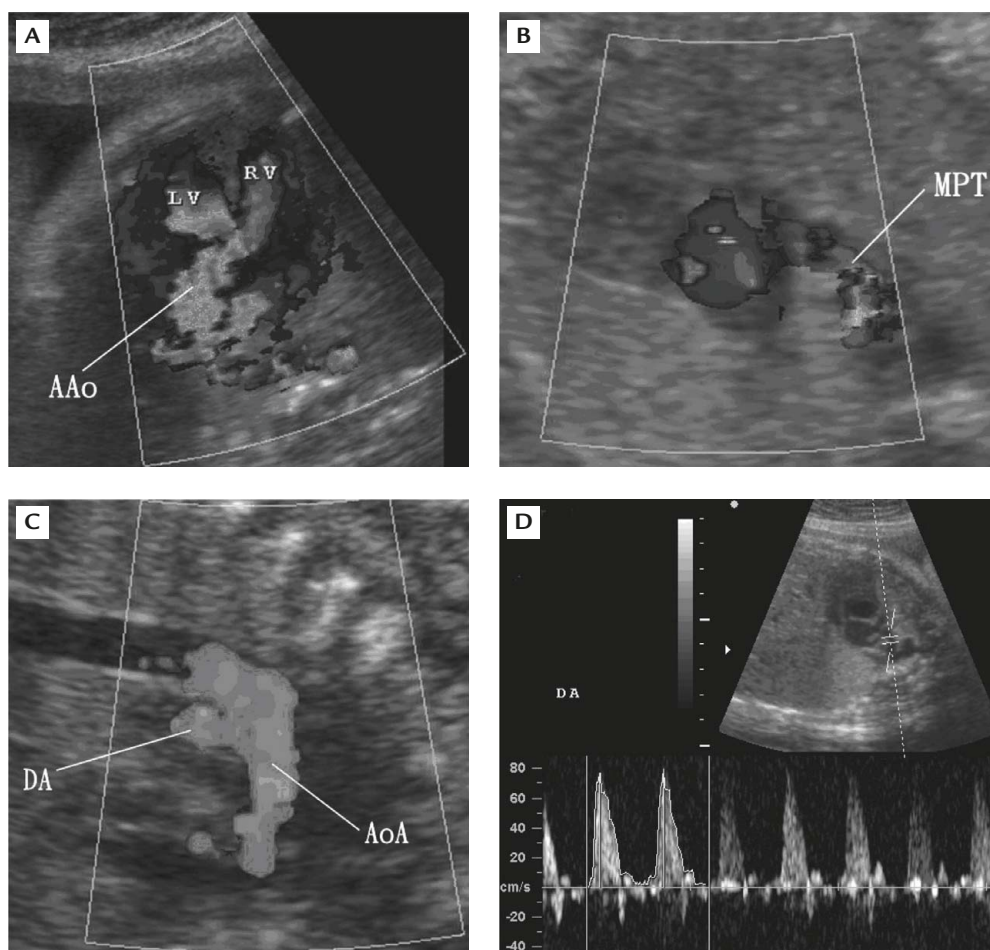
(A) The 5-chamber view of color flow mapping shows a ventricular defect and an enlarged ascending aorta (AAo). (B) The short-axis view of the fetal heart shows that the pulmonary trunk artery (MPT) is fed with reversed blood flow from the ductus arteriosus. (C) The longitudinal aortic arch view shows an enlarged ductus arteriosus (DA) that is fed with aortic flow from the aortic arch (AoA). (D) Doppler flow mapping of a short-axis view of the fetal heart. The directionality of the blood flow is reversed to normal. LV = left ventricle; RV = right ventricle.
